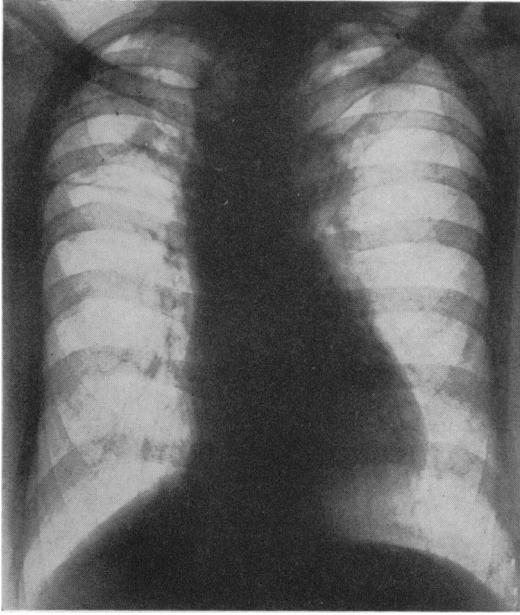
Case 2: Anterior radiograph at age 46 showing elevation of apex of heart, prominence of infundibulum, fibrosis of apices of lungs, high position of main pulmonary artery branches, and clarity of lung fields.
